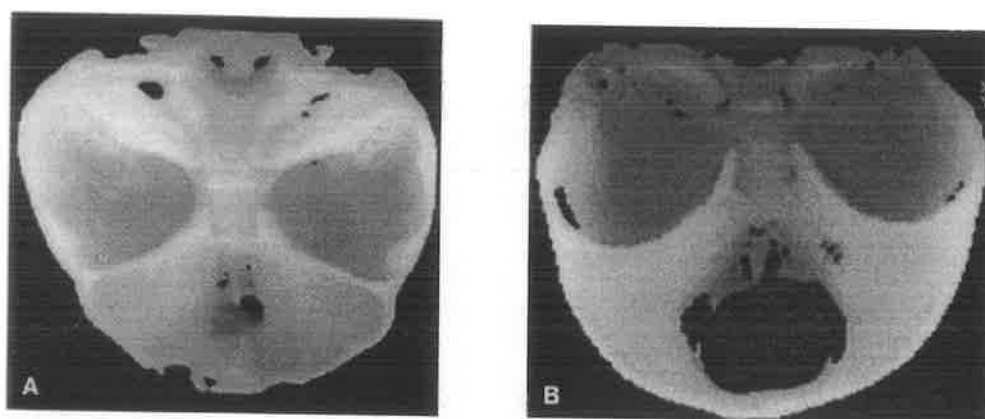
Three-dimensional computed tomography scan of exit holes of sincipital encephaloceles from the anterior cranial fossa between the frontal and ethmoid bones. A Naso-orbital encephalocele. B Naso-frontal encephalocele.*
